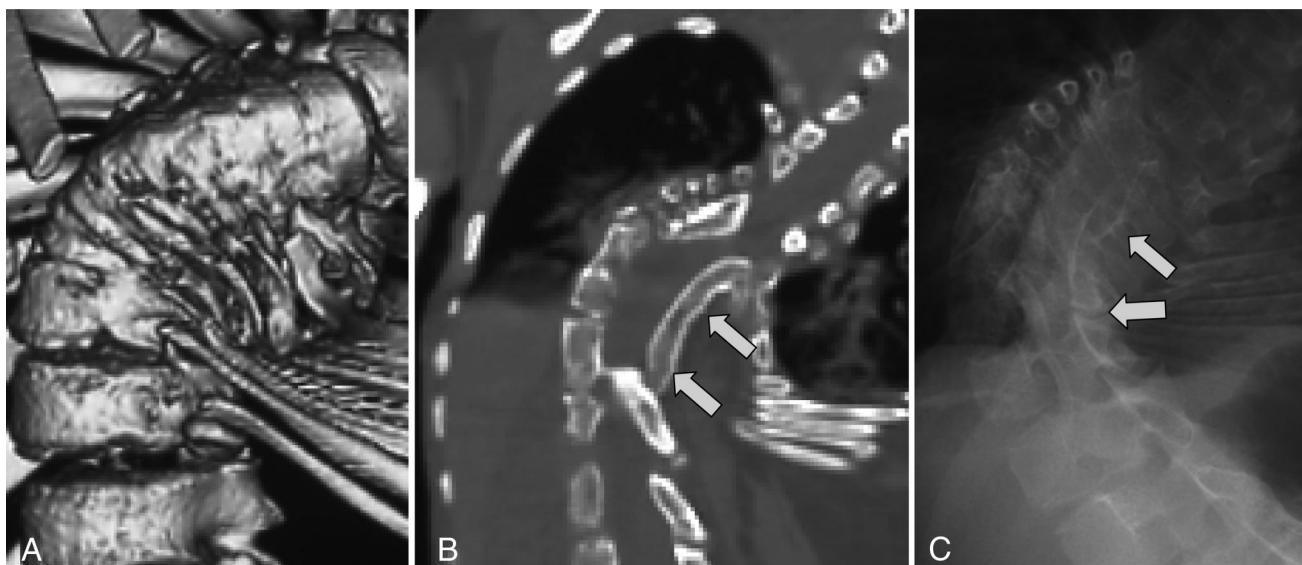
Unilateral unsegmented bar. A 7-year-old girl existing 128° of scoliosis. Three-dimensional CT image of thoracic spine (A) shows a severe scoliotic curvature with severely lateral wedged vertebrae. The long bar can be easily recognized on the coronal reconstructed image (B) and plain radiograph image (C) (arrows).
